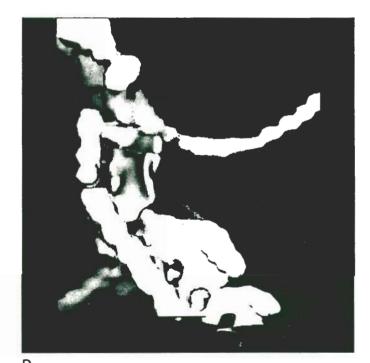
These three-dimensional CT images are viewed slightly from below. The anterior image (figure 2A) shows the Sprengel's deformity of the left scapula. The upper cervical vertebrae are obto 3D-CT scured by the occiput. The posterior image (figure 2B) reveals fusion finition of anomalies involving the posterior elements. There is spina bifida in contained the upper cervical region. Midline sagittal sections are viewed to the sing an al- patient's left (figure 2C) and right (figure 2D), respectively. These more 2s." With
